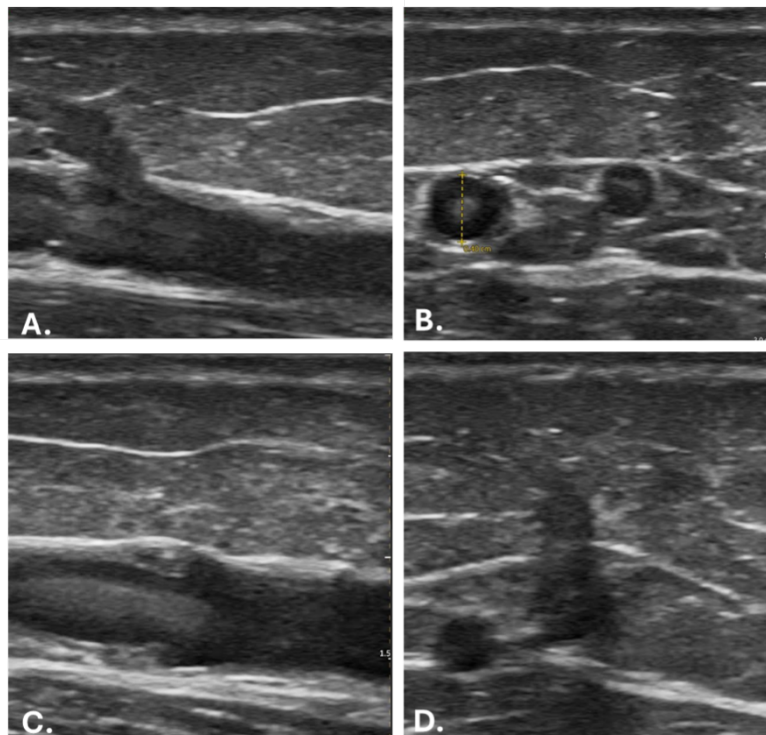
Ultrasound images of the great saphenous vein (GSV).
